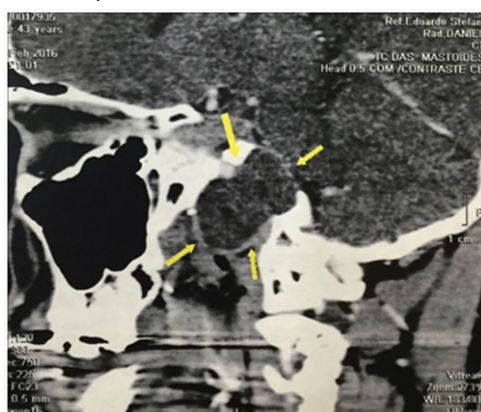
Preoperative sagittal contrast CT Scan with a right expansile petrous apex lesion.
